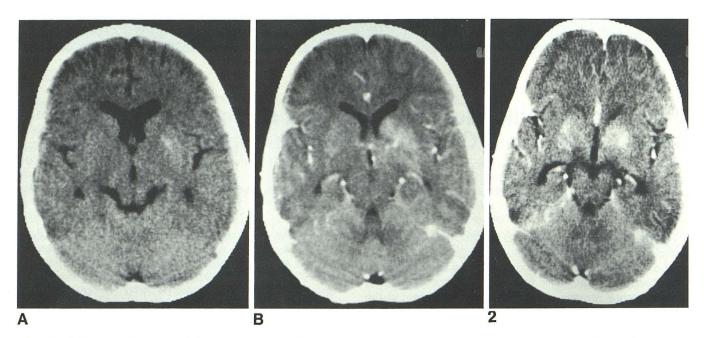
A, Noncontrast-enhanced CT scan shows generalized cerebral atrophy with secondary enlargement of ventricular system and a discrete density consistent with calcification in left basal ganglia.
